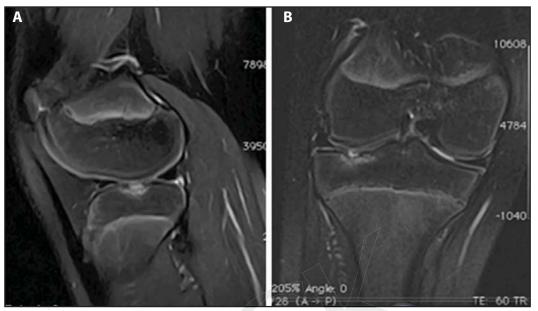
(A) Sagittal and (B) coronal T2-weighted MRI of 10-year-old female with open physes with subchondral bone marrow edema.
